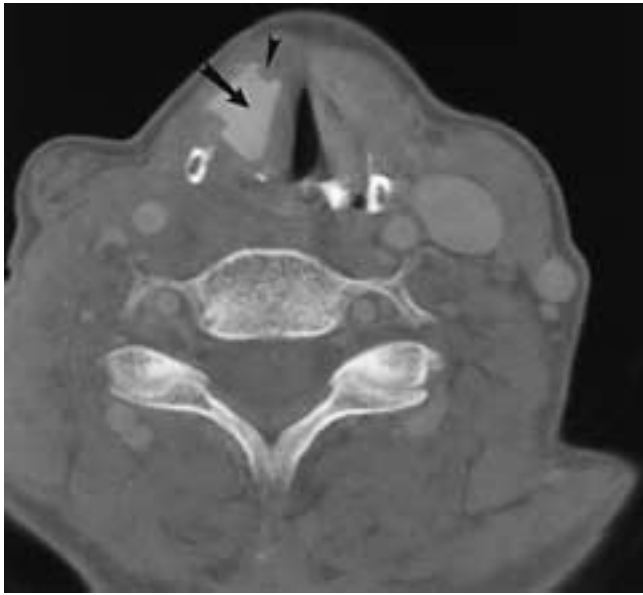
Axial CT, silastic stent for vocal cord paralysis. The preshaped silastic stent (arrow) is used to add bulk to the paralyzed cord. The notches seen in the anterior (arrowhead) and posterior edges stabilize the stent in the surgical opening in the thyroid cartilage.
